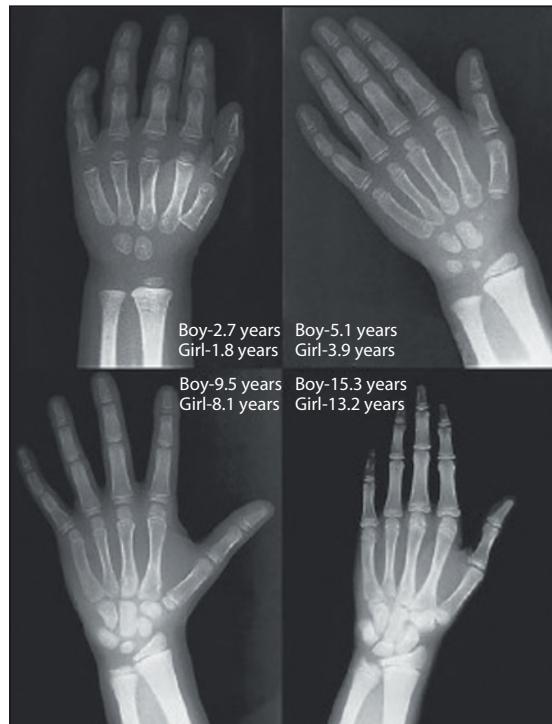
X-rays of the left hand and wrist to determine bone age. This technique allows assessment of skeletal maturation from the time of appearance of the epiphyseal centres, using a standardized rating system. The child's height can be compared with skeletal maturation and an adult height prediction made. The ages shown are the bone age of each X-ray.
